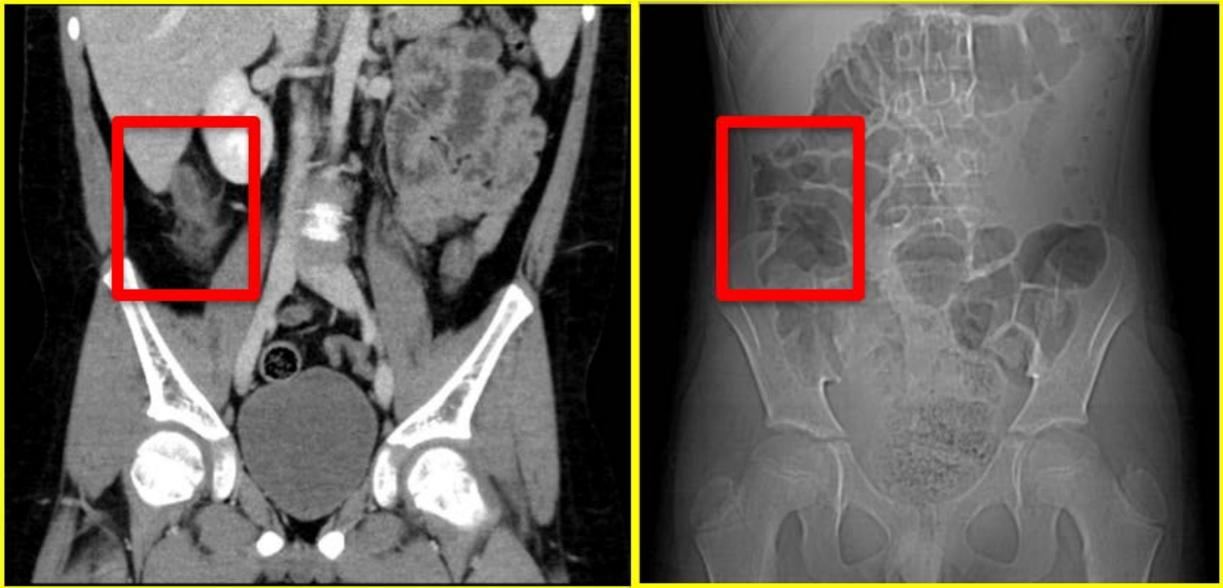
Coronal CT of the abdomen/pelvis with the red line depicting the area of FOV that is reduced with the low FOV protocol.
